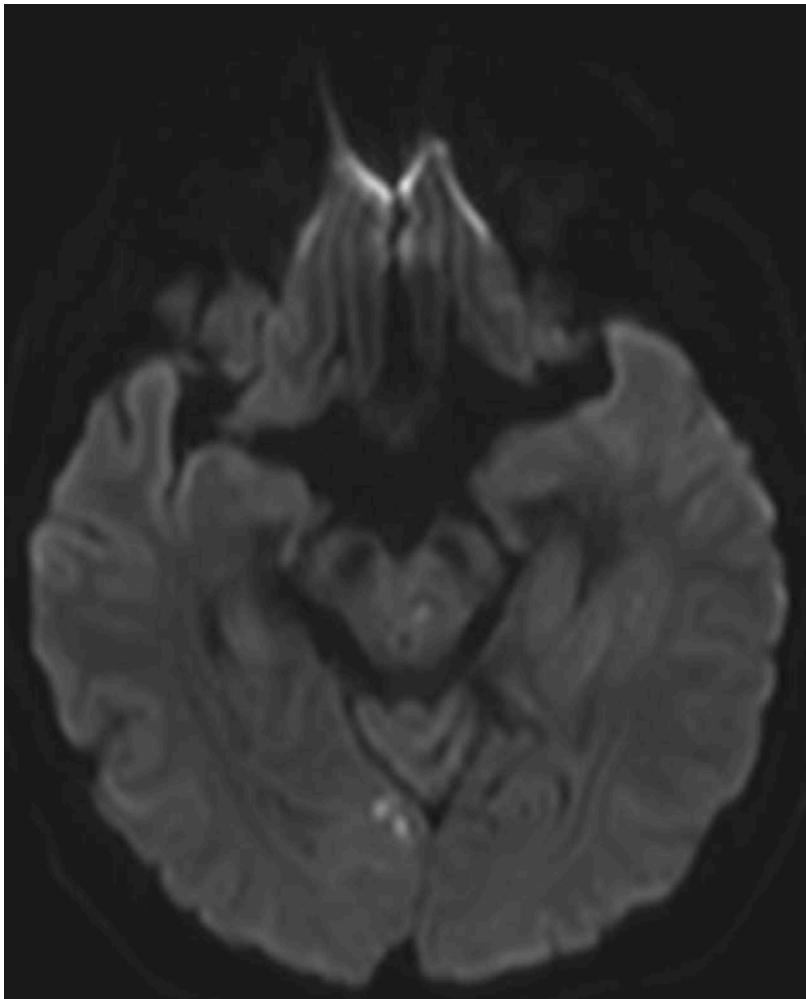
Small occipital and brainstem lesions with signal restriction on presentation - Diffusion Weighted Image (DWI)
